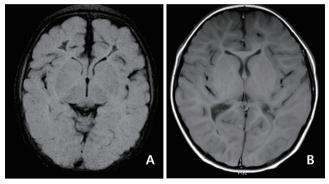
Serial follow-up magnetic resonance imaging. (A) Cystic changes was observed in white matter in the frontal lobe at 2.5 months after seizure onset. (B) Note the decreased cerebral white matter volume at 2 years after onset of symptoms. Panels show T2-weighted fluid-attenuated inversion recovery image (A) and T1-weighted spine echo sequence (B) from a same patient who suffered neonatal seizures with rotavirus infection (unpublished data from Gyeongsang National University of Hospital).
